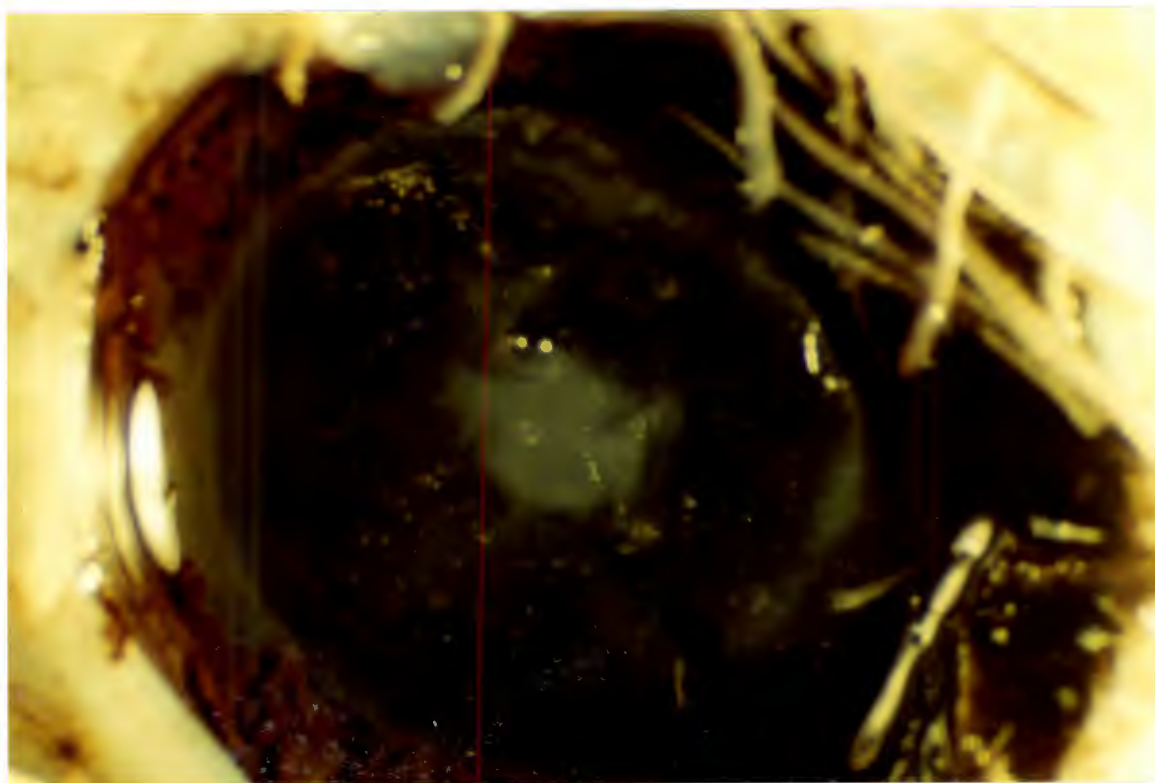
HUMAN LENS AFTER TWO SECOND EXPOSURE TO ULTRASOUND AT 81.6 KHZ
